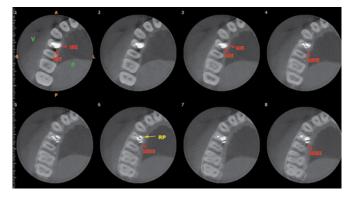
CBCT endodontic treatment follow-up (Dec/2014) showing in axial slices, at the level of the cervical third in PR, endodontic material overfilling and spreading towards the external lateral wall, both palatally and distally.
